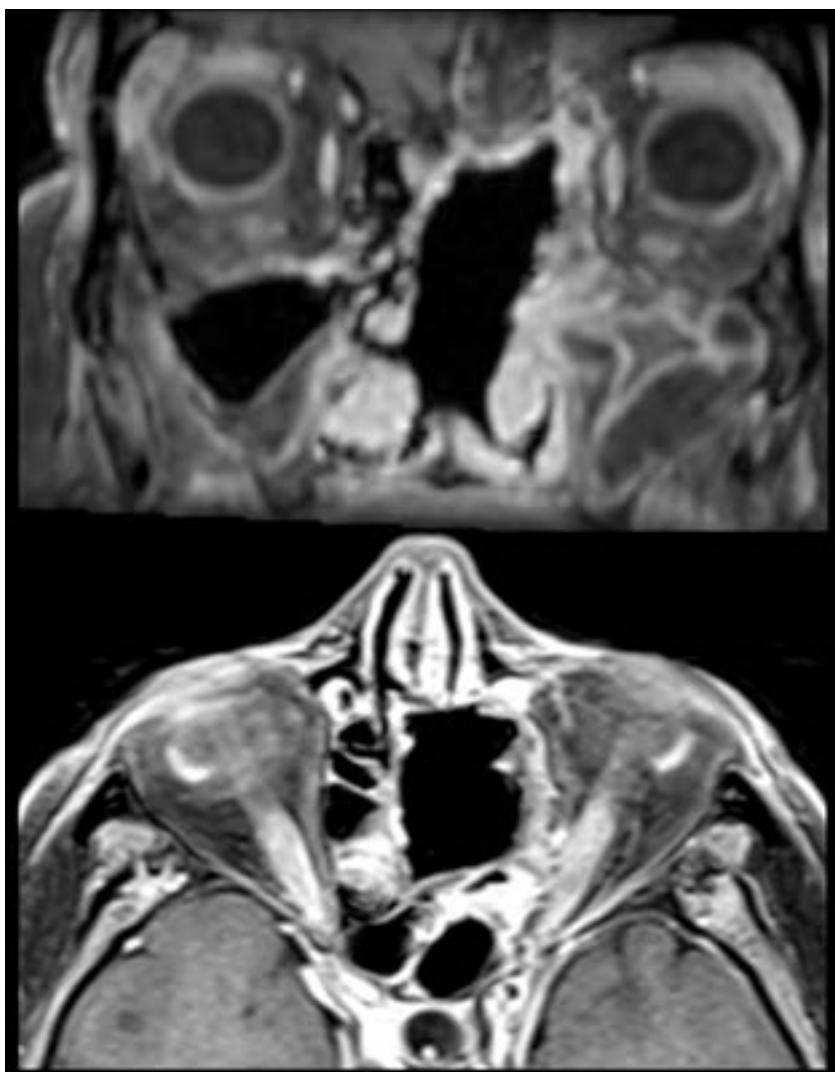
Six-months post-operative MRI.
